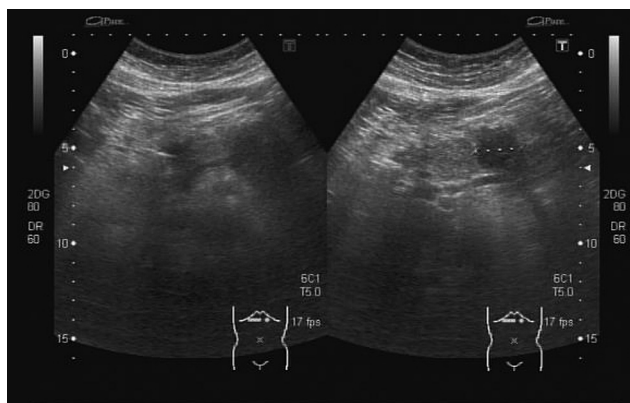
Abdominal ultrasonogram during the first admission. The sonogram shows a cystic lesion 2 cm in the body of the pancreas.
